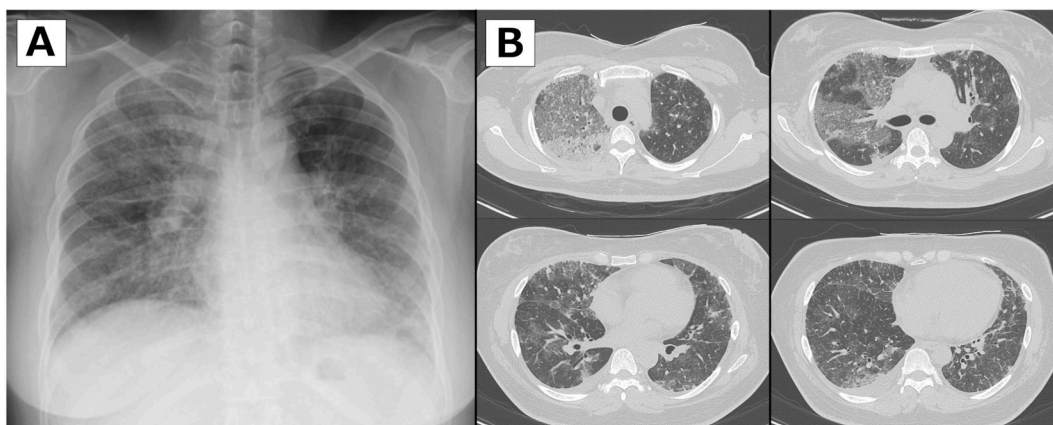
(A) Bilateral infiltrations were observed on chest radiography. (B) Diffuse ground-glass opacity with interlobular septal thickening and bilateral small pleural effusions were evident on chest computed tomography.
